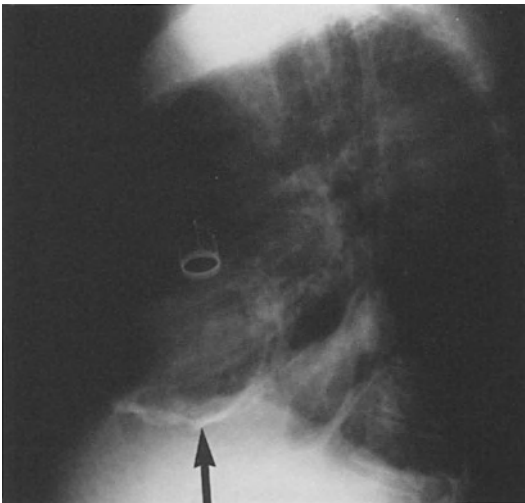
Lateral chest X-ray in postoperative constrictive pericarditis demonstrating pericardial calcification (arrow).
